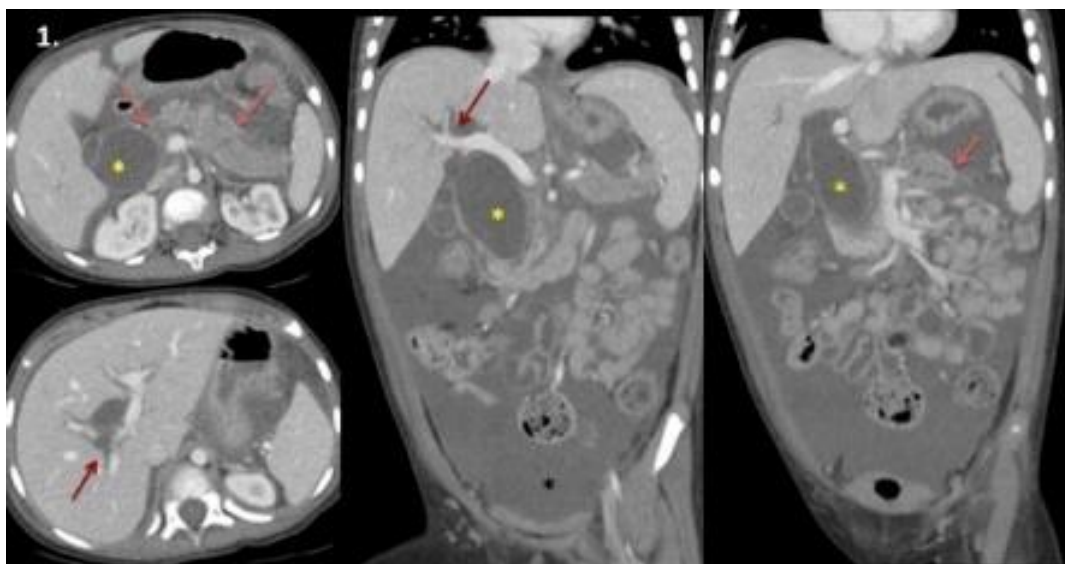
An abdominopelvic contrast CT revealed a fusiform dilation of extrahepatic bile duct, a proximal intrahepatic duct dilation, a diffuse pancreatic parenchymal enlargement with multifocal parenchymal necrosis and a large volume of ascites.
